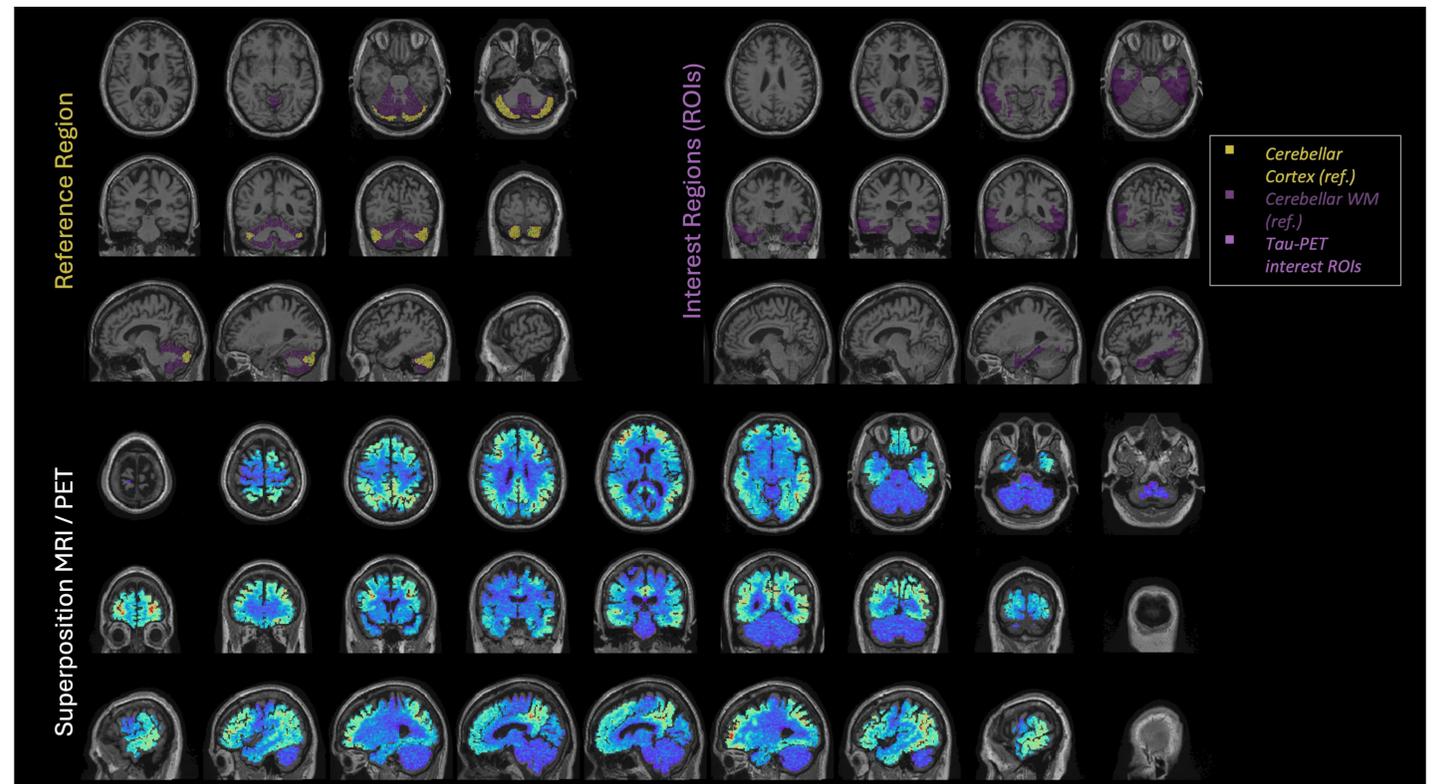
Automated T1-MRI/Tau-PET co-registration quality control for a representative subject, showing MRI/PET alignment (top), cerebellar reference region masks (bottom left, yellow/purple), and Braak-relevant interest region masks (bottom right, purple), generated without manual input.
